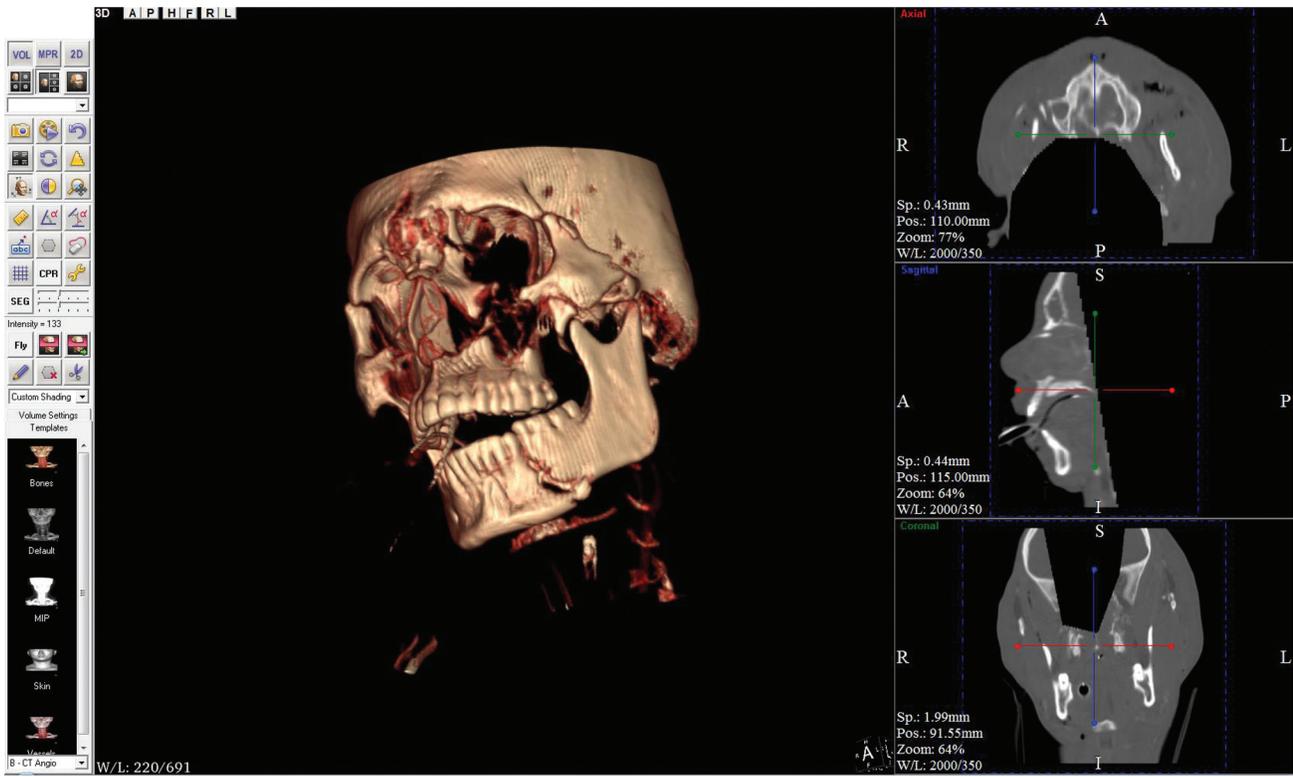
Preoperative computed tomography scan.
